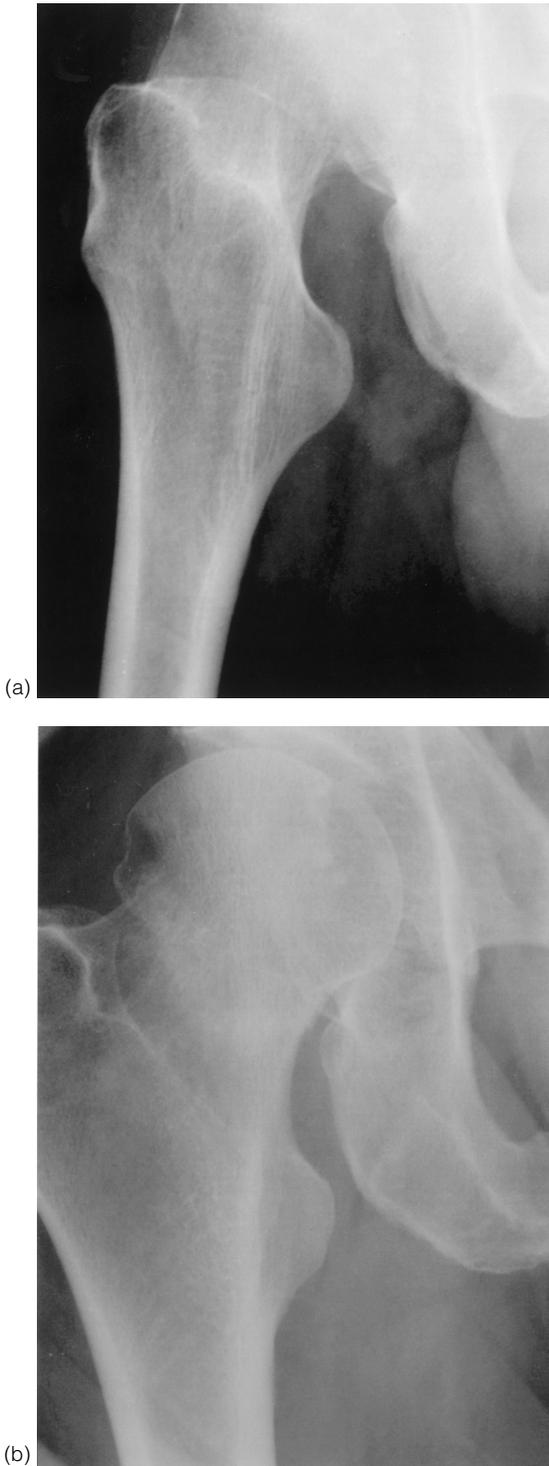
(a,b) An undisplaced intracapsular fracture, which only becomes apparent on an x-ray take in 10° internal rotation
